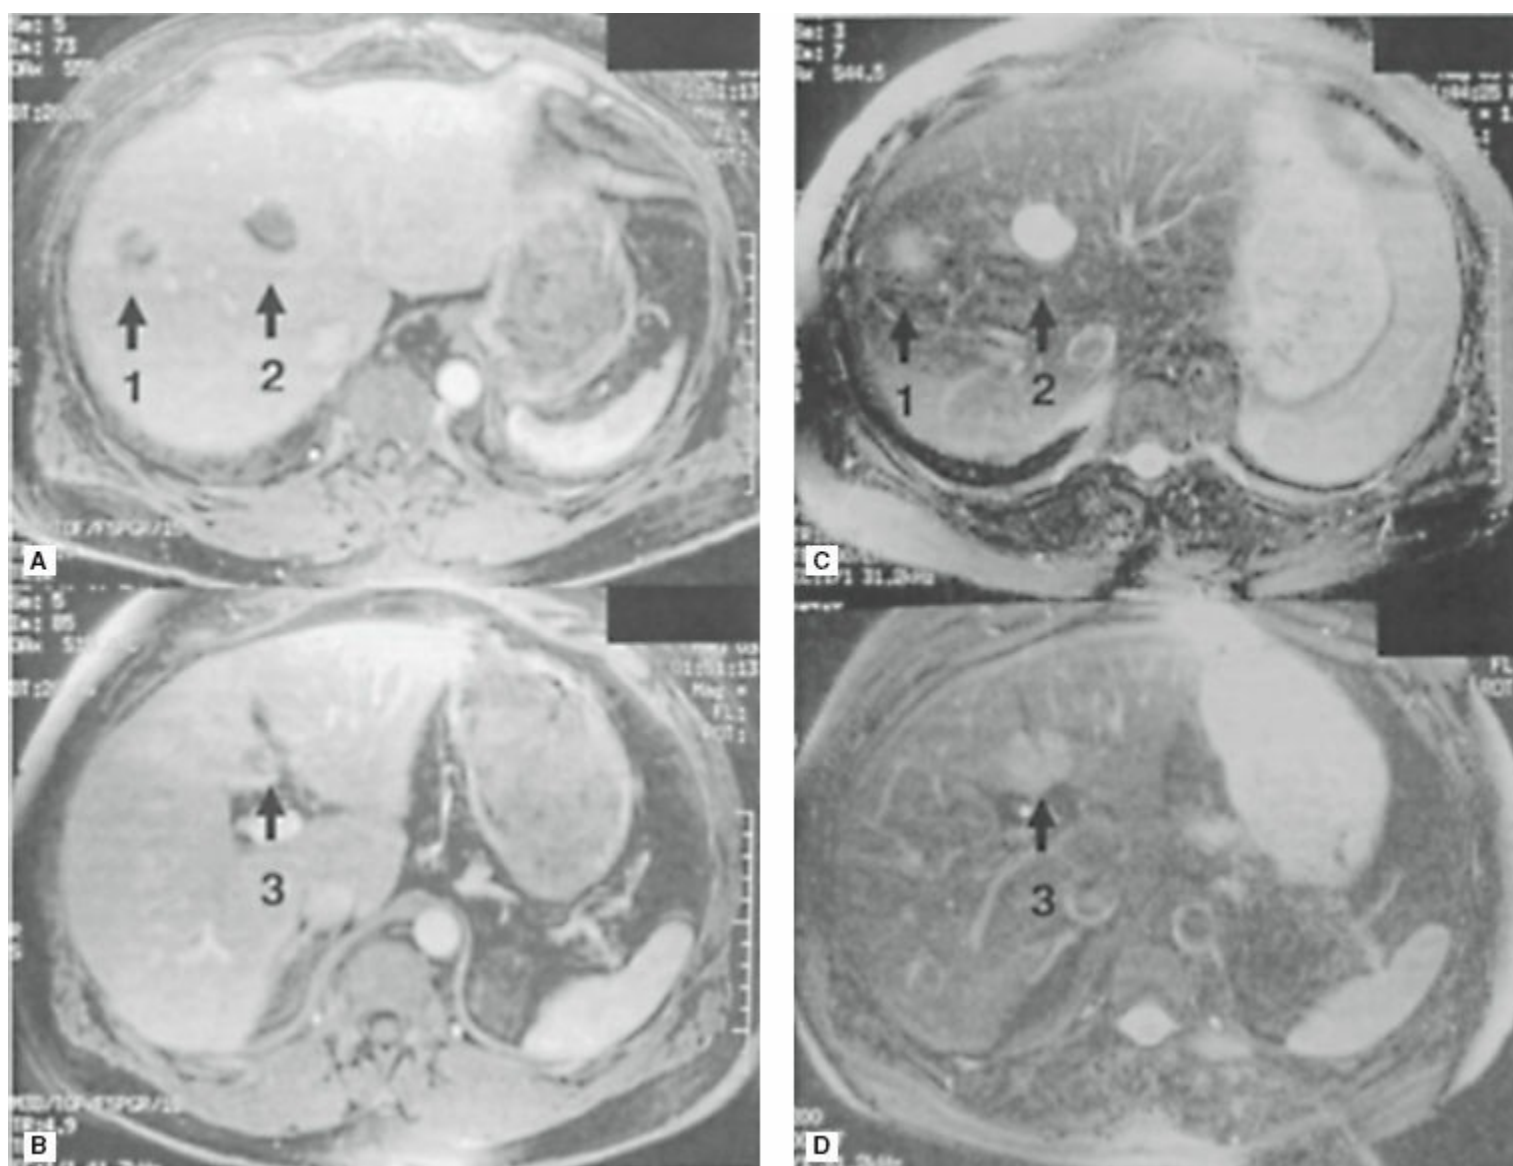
A,B: T1-weighted magnetic resonance imaging (MRI) with gadolinium from the same patient as in Figure 57-14 with history of colorectal cancer and three lesions in the liver. Lesion 1 in segment VIII is irregular and rim enhancing and was a colorectal cancer metastasis. Lesion 2 straddling segments IV and VIII has smooth borders, is not rim enhancing, and was found to be a cyst. Lesion 3 straddling segments IV and III across the umbilical fissure is irregular, rim enhancing, and was a colorectal cancer metastasis. C,D: T2-weighted MRI from the same patient with history of colorectal cancer and three lesions in liver. Lesion 1 in segment VIII is irregular and mildly bright and was a colorectal cancer metastasis. Lesion 2 straddling segments IV and VIII has smooth borders, is very bright, and was found to be a cyst. Lesion 3 straddling segments IV and III across the umbilical fissure is mildly bright and was a colorectal cancer metastasis. Colorectal metastases and many tumors are mildly bright on T2-weighted MRI, whereas cysts and hemangiomas are typically very bright.
